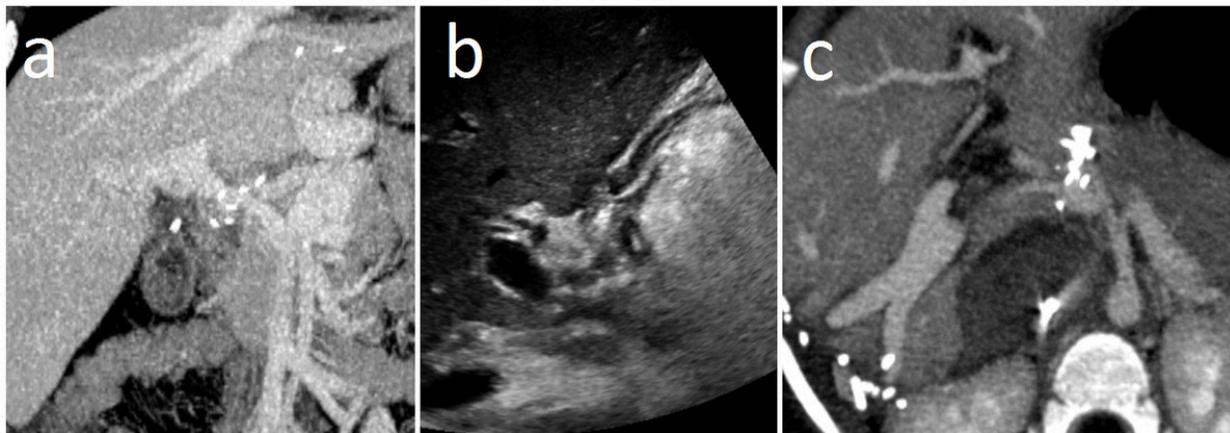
Venous complications. a) Coronal CT with maximum intensity projection showing a portal stenosis in the place of the anastomosis, note the radiologic correlation with the b) ultrasonography; c) Axial CT with Maximum Intensity Projection showing portal thromboses (arrow) next to the anastomosis in a PLT.
